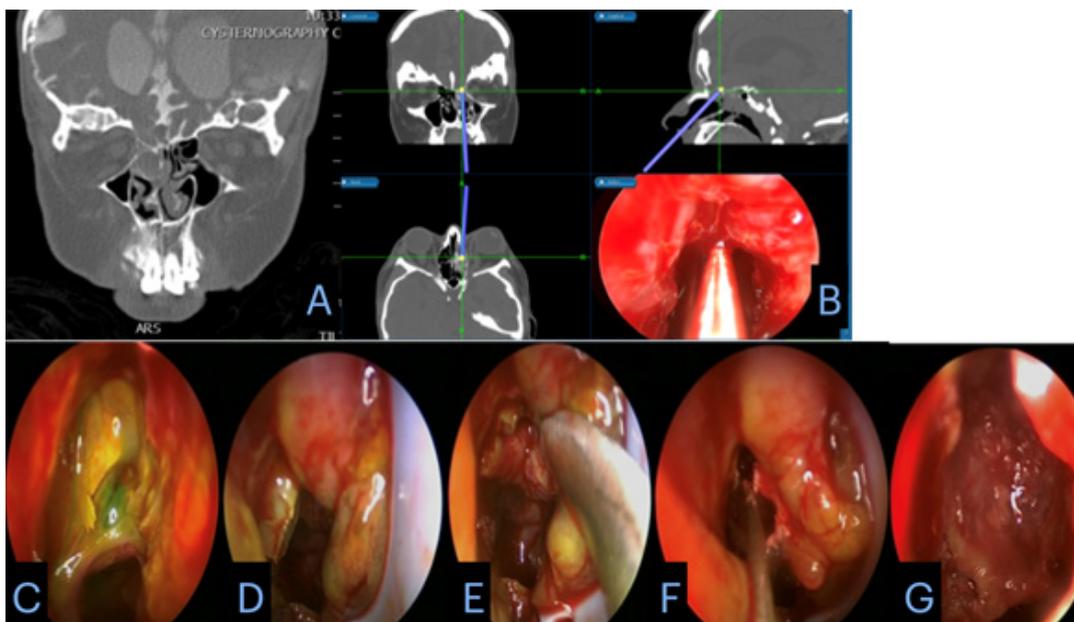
(A): Large right ethmoid meningoencephalocele on CT cisternography, (B): Image guided endoscopic endonasal excision and repair of skull base defect, (C): Intraoperative view of the meningocele with positive fluorescein dye of CSF leak, (D): First layer of septal bone underlay graft reconstruction, (E): Second layer of free mucosal graft underlay reconstruction, (F): Third layer middle turbinate pedicle rotation flap reconstruction, (G): Final cavity post excision MEC and three layers skull base reconstruction.
